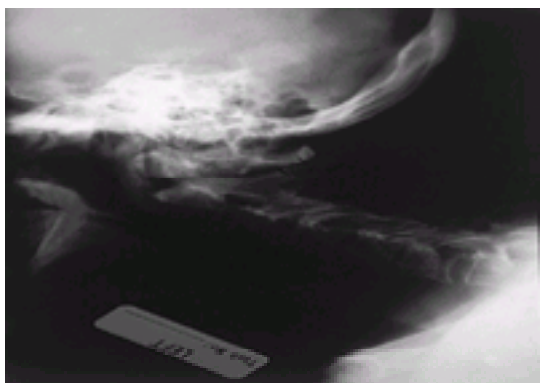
Lateral radiographs showing posterior displacement of type II odontoid fracture.
